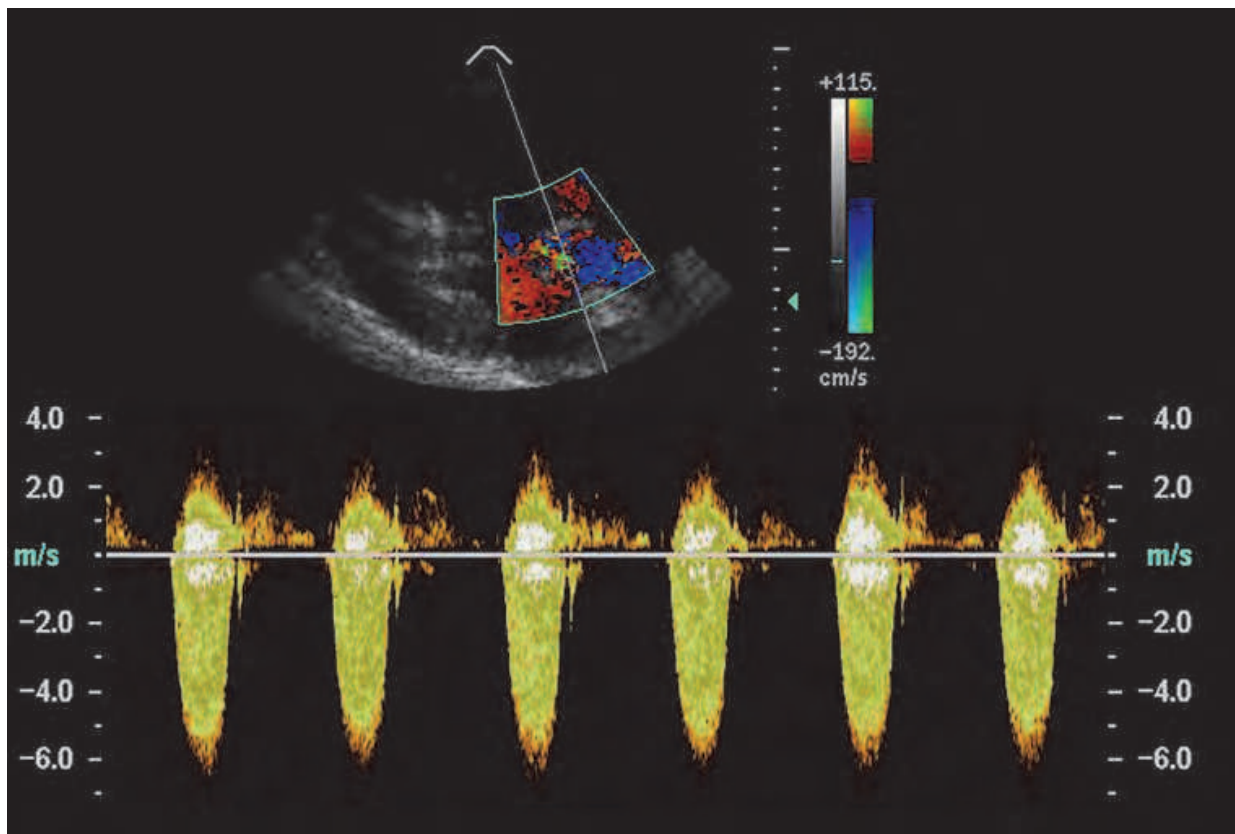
Continuous wave Doppler in a severe aortic stenosis. A high velocity profile (6m/s) is depicted.
